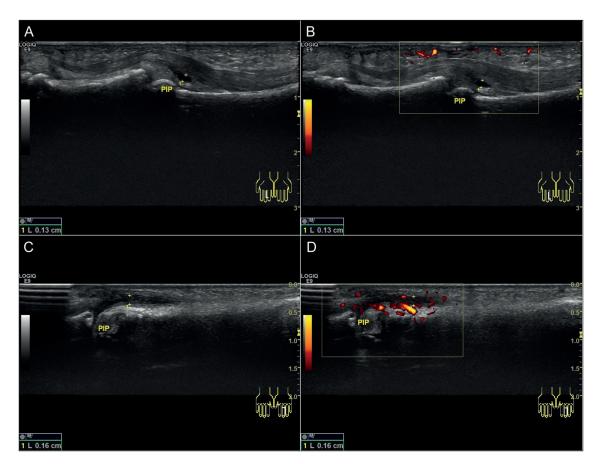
Ultrasonic characteristics of subclinical synovitis in RA patients with disease in clinical remission. Synovitis is present in 2 different PIP joints. One shows mild synovitis with no power Doppler signal (GSUS=1, PDUS=0, Figure A and B) and the other shows moderate synovitis with hypervascularized signal (GSUS=1, PDUS=1, Figure C and D). RA: Rheumatoid arthritis, GSUS: grayscale ultrasound, PDUS: Power Doppler ultrasound, PIP: proximal interphalangeal.
